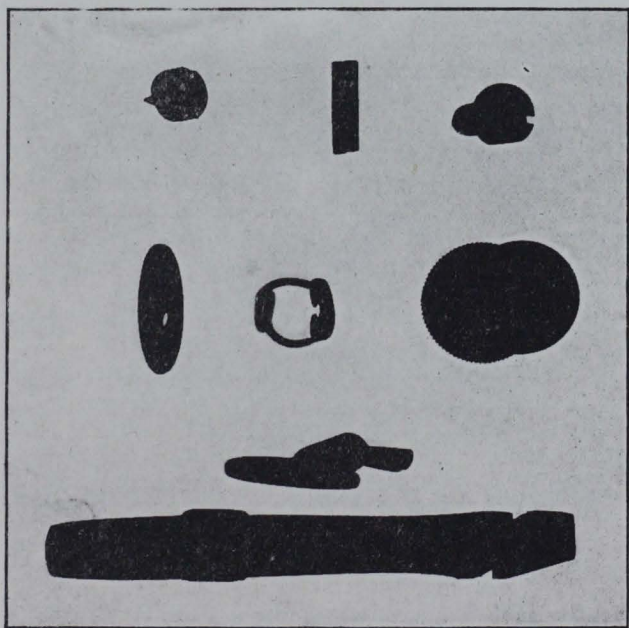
RADIOGRAM OF SAME OBJECTS AS IN FIG. 54, WITH X-RAY TUBE
